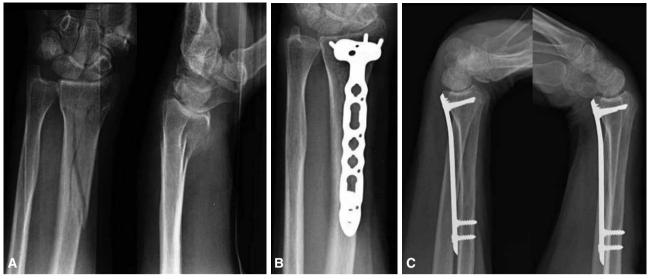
A. Anterior-posterior and lateral X-rays. Type 23A3 fracture. B. Reduction and osteosynthesis with a 4 x 6-hole locked T-plate and bone healing at month 2. C. Functional X-rays five years after the surgery.
